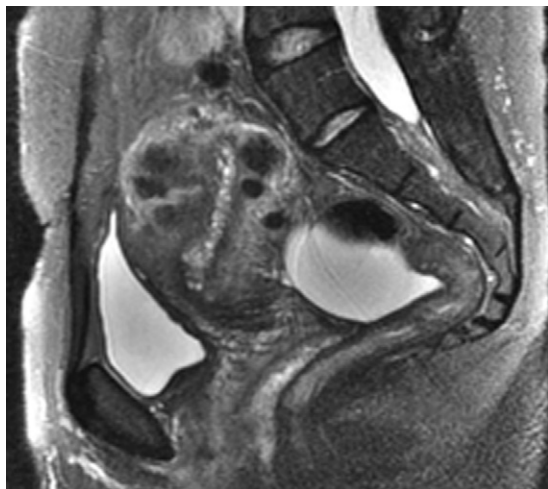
Endometrial tamoxifen changes. The sagittal T2-weighted fat-suppressed image in a patient on tamoxifen shows the typical cystic endometrial thickening.
